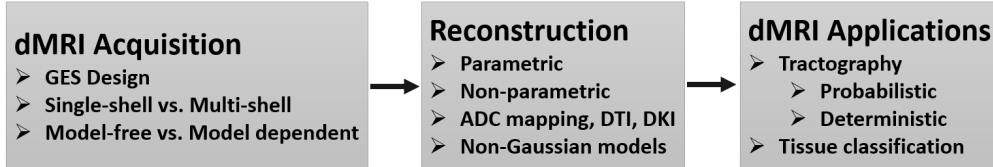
Diffusion MRI: Three main steps and corresponding terminology.
